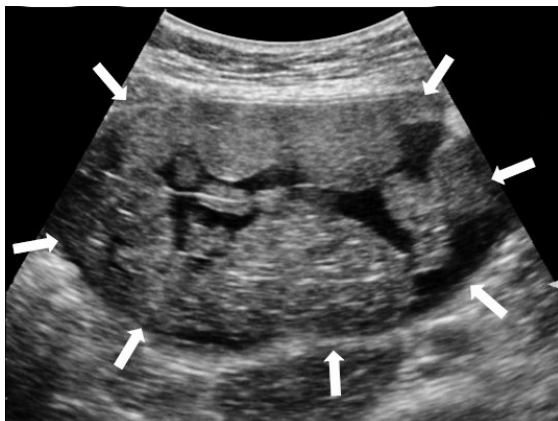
Transabdominal pelvic ultrasonography image of a 50-year-old woman with right iliac fossa pain shows a 12.6 cm × 11.7 cm × 7.8 cm well-defined cystic mass in the right lower abdomen, containing multiple round, solid-looking hypoechoic nodules within it (white arrows). The patient subsequently underwent total hysterectomy and bilateral salpingo-oophorectomy, and the mass was found to be a right ovarian cystic teratoma.
